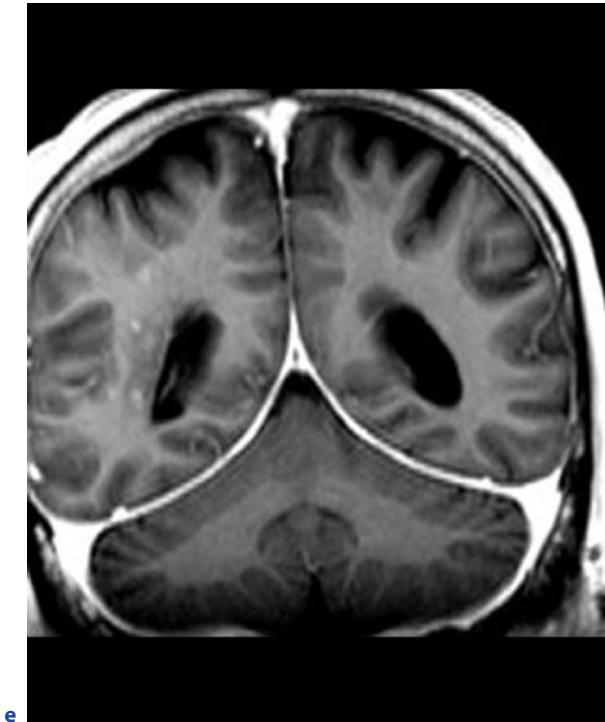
(continued) Panarteritis nodosa (PAN). A 65-year-old man with loss of vigilance and intermittent hemiparesis of the left side. Biopsy of the cerebellum and meninges yielded pathological features compatible with those of cerebral vasculitis. He died 3 months after hospital admission. e Coronal T1-weighted image after contrast administration. Irregular subcortical and cortical signal changes of the right hemisphere (a). Patchy hyperintense areas on T2-weighted images in the right cerebral hemisphere (b). Multiple right-hemispheric contrast-enhancing lesions, patchy in the periventricular white matter and garland-like in the cortex of the right occipital cortex (c,d). Punctate nodular contrast enhancement in the white matter of the right hemisphere (e)
